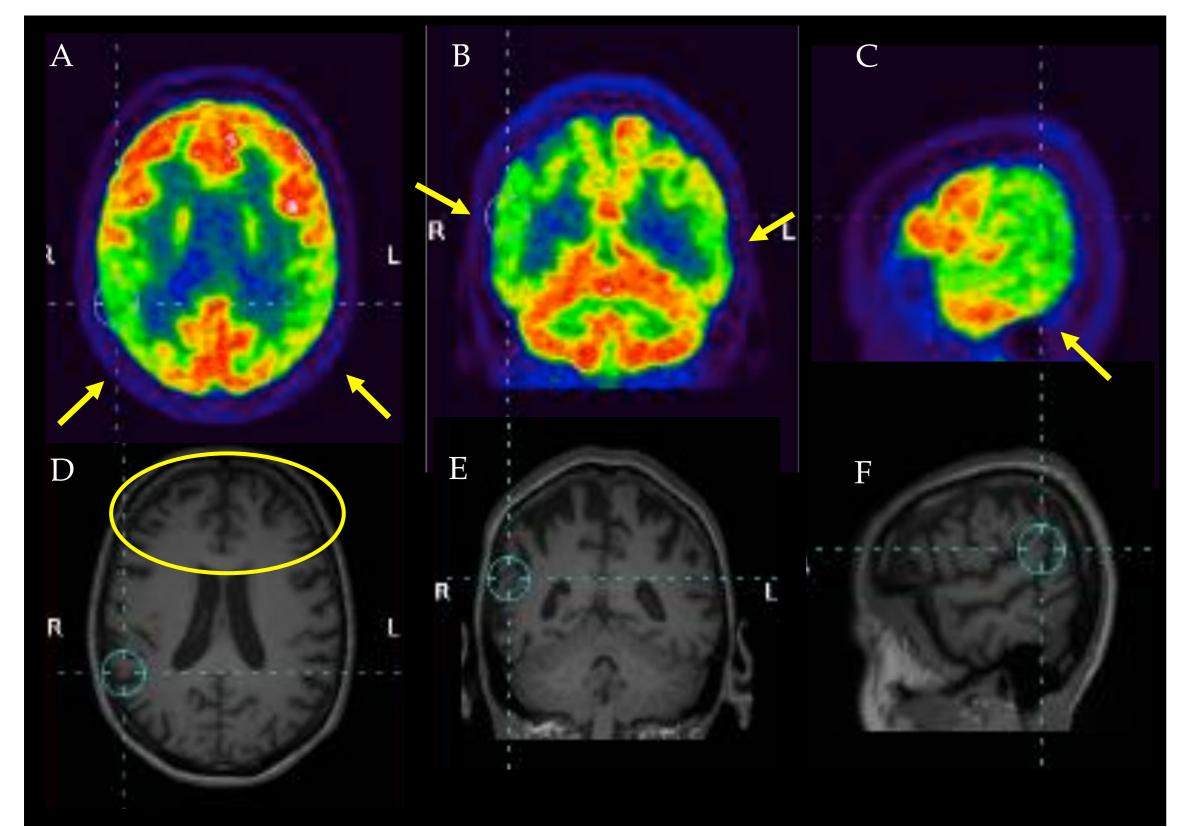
PET/MRI Hybrid imaging (co-acquired images), axial (A, D), coronal (B, E), and sagittal (C, F) scan. Arrows point to bilateral parieto-temporal hypometabolism, no correspondent cortical atrophy was detect at visual qualitative analysis; mild mesial frontal atrophy was noted (circle)
